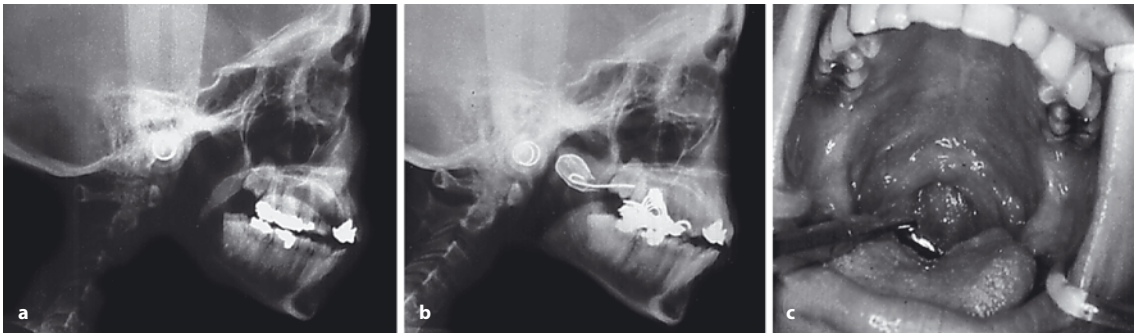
a Lateral radiograph of the patient in Fig. 18.4 prior to stimulation saying “E.” b The palatal lift prosthesis in position elevating the soft palate. c Note the increase in the degree
